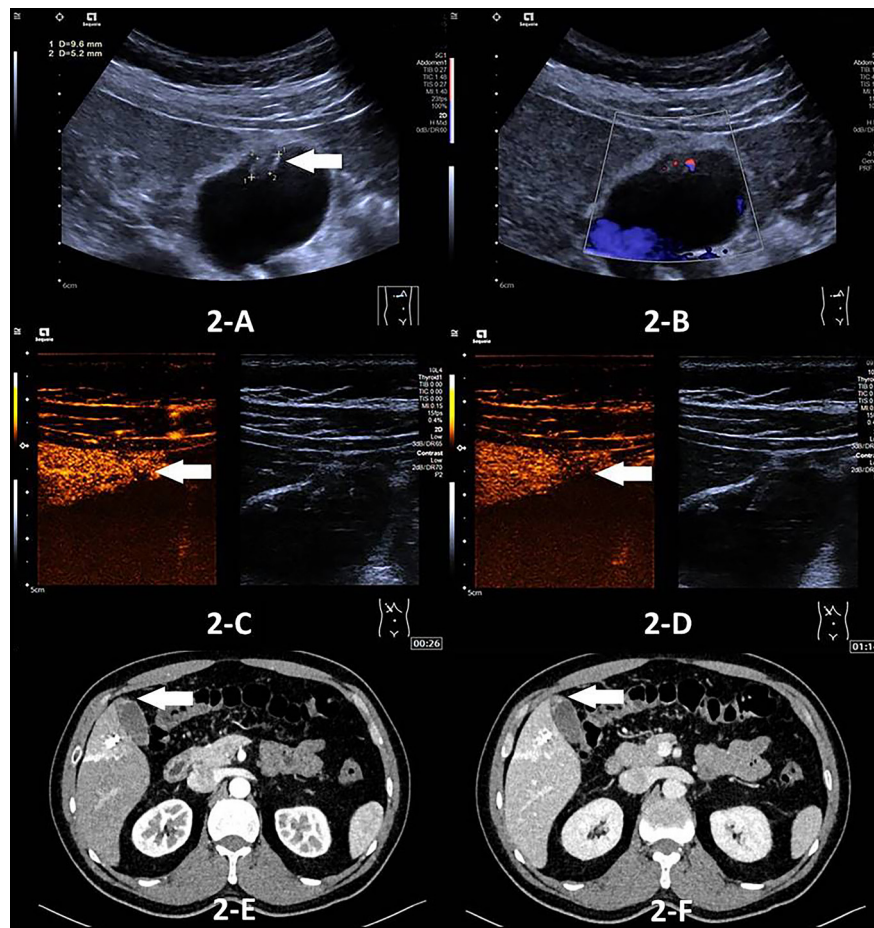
A 44-year-old man with a 9.6×5.2 mm xanthogranulomatous cholecystitis diagnosed using CEUS and CECT. (A-B): A mildly hyperechoic lesion fundus of GB (arrow) and Color Doppler blood flow imaging (CDFI) showed a few strip-like flow signals on conventional ultrasound. (C-D): No obvious contrast agent filling was observed throughout, and a small amount of GB wall destruction was visible (arrows) on CEUS. (E-F): The lesion showed homogenous iso-enhancement, similar to the liver (arrow) in the arterial phase and prolonged enhancement (arrow) in the venous phase on CECT.
